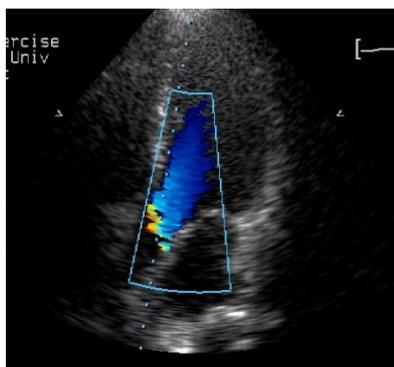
Apical 5 chamber view of the heart. Blue jet represents the blood moving away from the ultrasound beam through the aortic valve.
